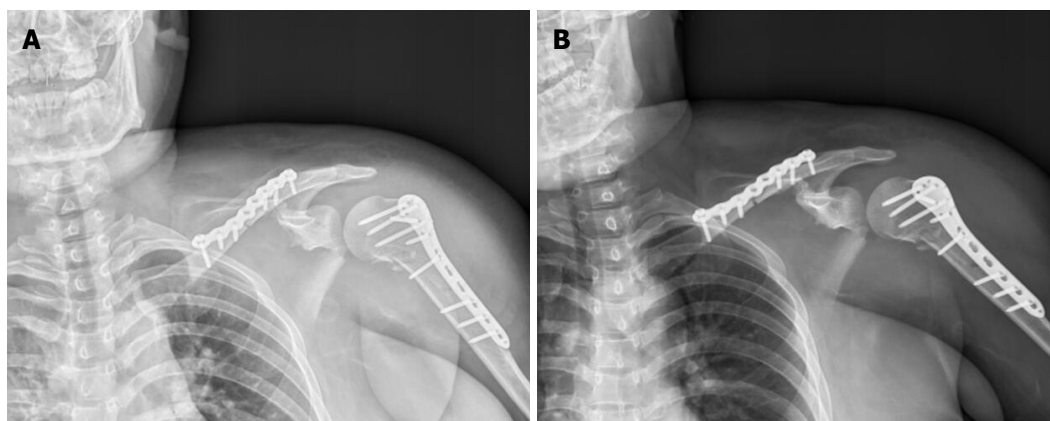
Postoperative radiographs showing reduction and locking plate. A: Positive slice; B: Oblique slice.
